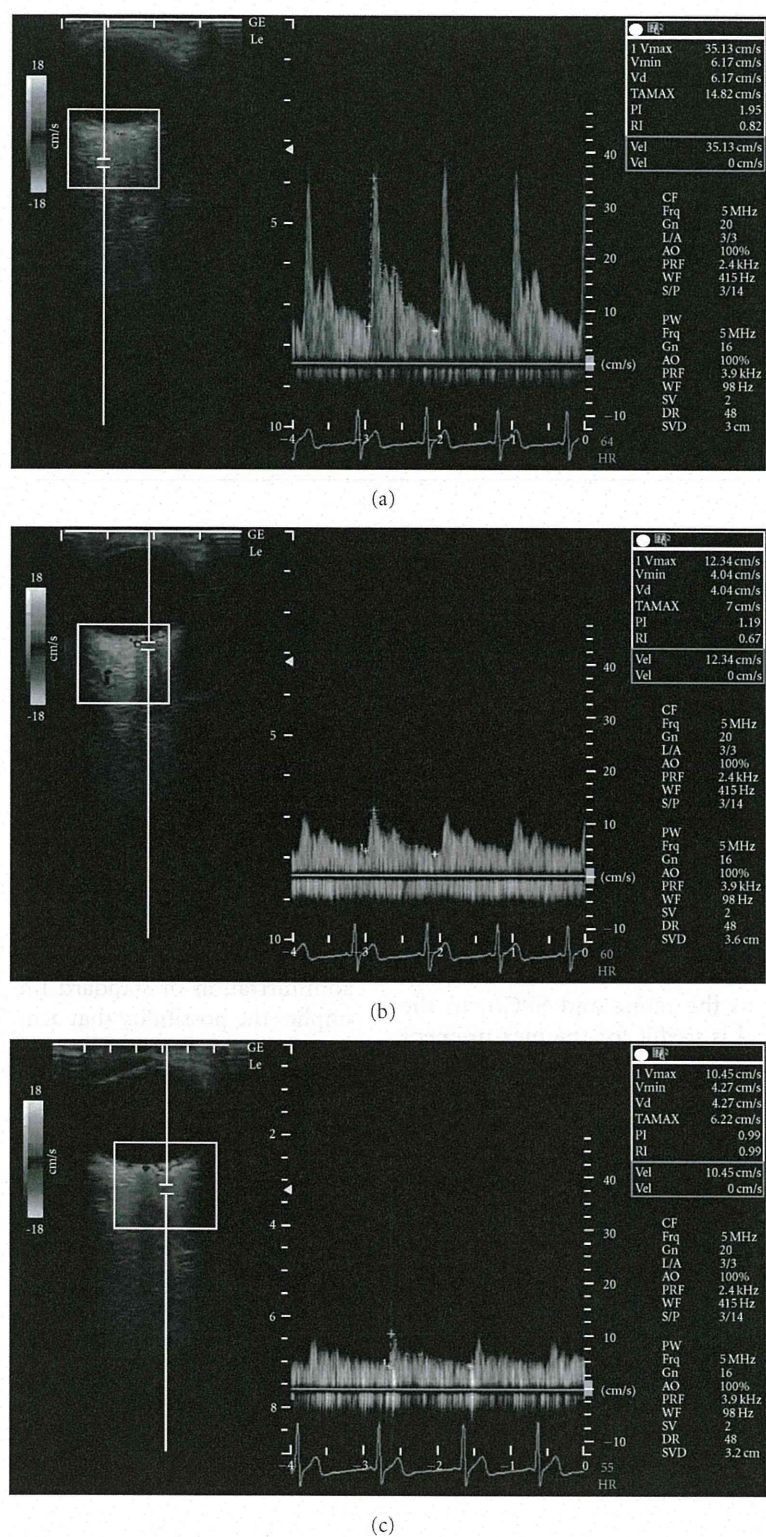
Horizontal scans by color Doppler imaging through the globe showing the (a) ophthalmic artery, (b) central retinal artery, and (c) short posterior ciliary artery.
